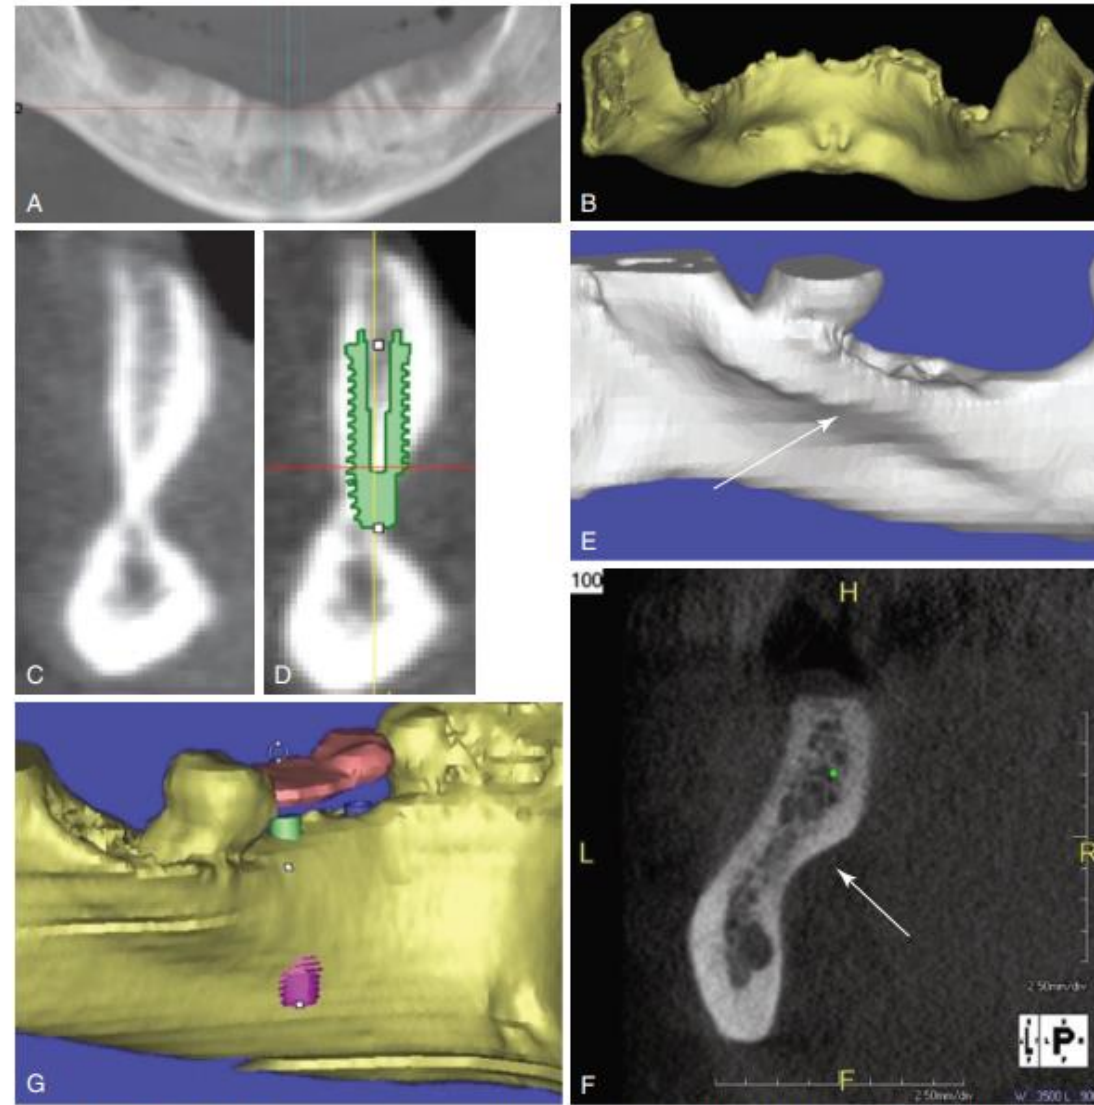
(A) CBCT panoramic view of anterior mandible depicting significant quantity of bone; (B–C) however, when viewed three-dimensionally, resultant hourglass concavities present in the anterior mandible; (D) complication of sublingual perforation which may lead to bleeding complications. (E) 3-D images depicting sublingual undercut; (F) cross section depicting significant undercut; and (G) complication of sublingual perforation.
